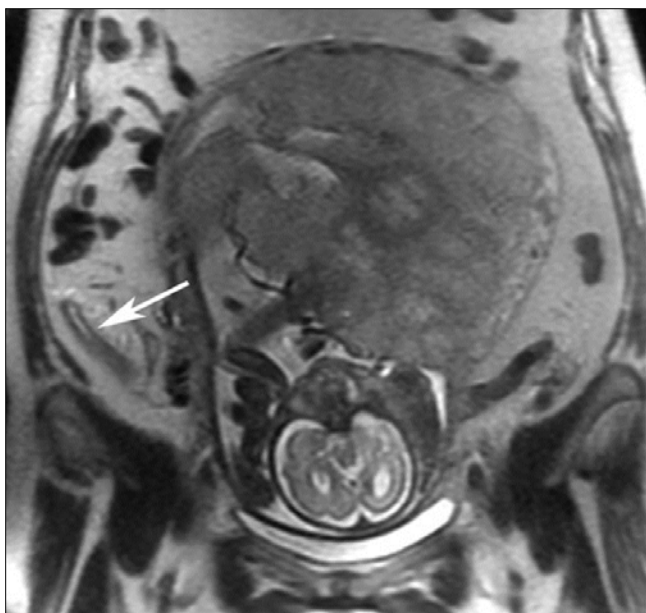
Acute Appendicitis within Sagittal MRI sequence in pregnant woman.
